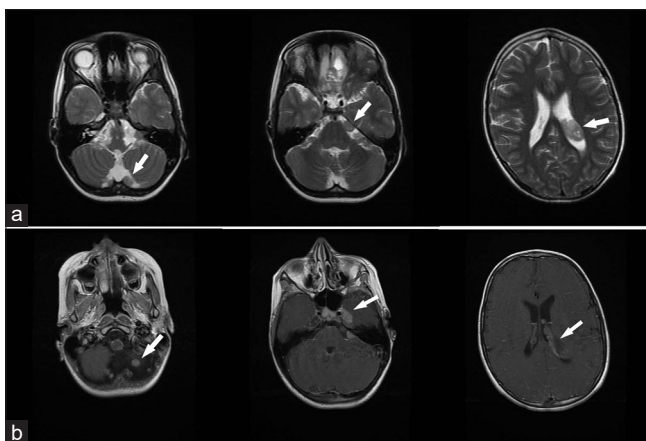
T2-weighted magnetic resonance image (a) and T1-weighted magnetic resonance image with contrast (b) showing multiple extra-axial enhancing masses at the posterior fossa, left lateral ventricle, cerebellopontine angles, and left Meckel cave
